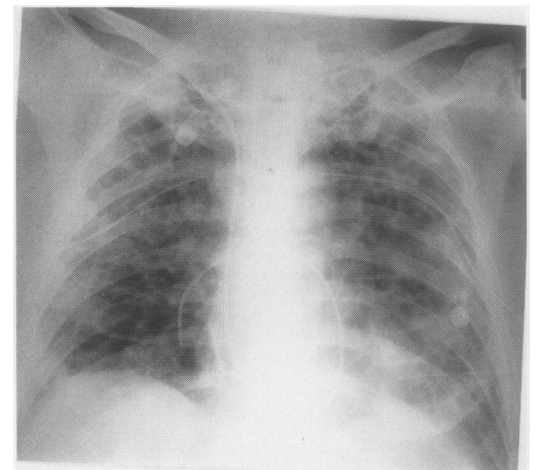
Chest radiograph on day 9 showing bilateral pneumatoceles, a pneumothorax on the left, and bilateral thoracic drains.
